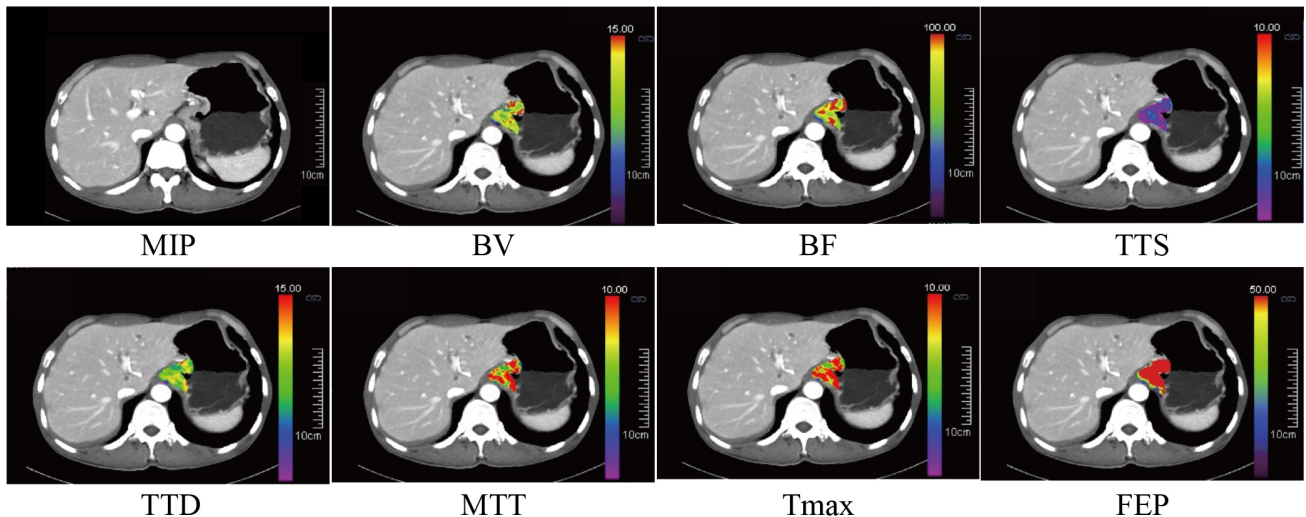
CT perfusion functional maps of a 51-year-old man with poorly differentiated carcinoma in the cardia of the stomach. MIP, maximal intensity projection; BV, blood volume; BF, blood flow; TTS, time to start; TTD, time to drain; MTT, mean transit time; FEP, flow extraction product.
